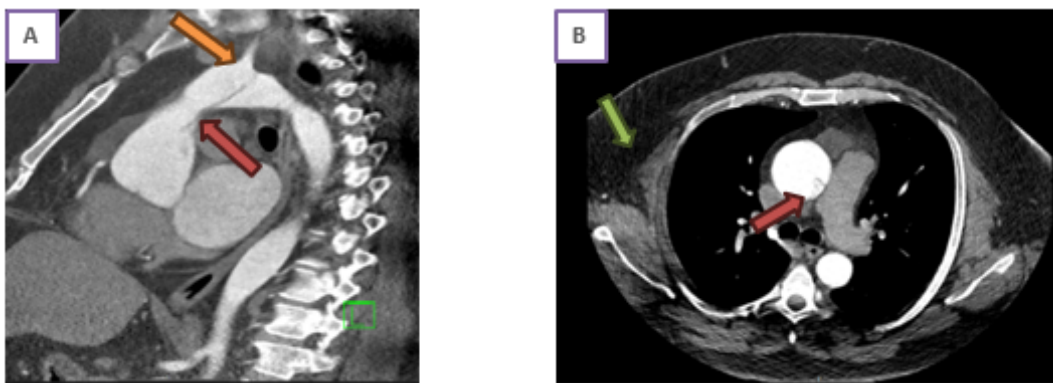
A: Sagittal CT scan plane (contrast-enhanced) showing Ascending aorta dissection (red arrow) and dissection of innominate artery (Orange arrow). B: Shows chest wall soft tissue (green arrow) and dilated ascending aorta with near transaction segment of proximal ascending aorta (red arrow)
